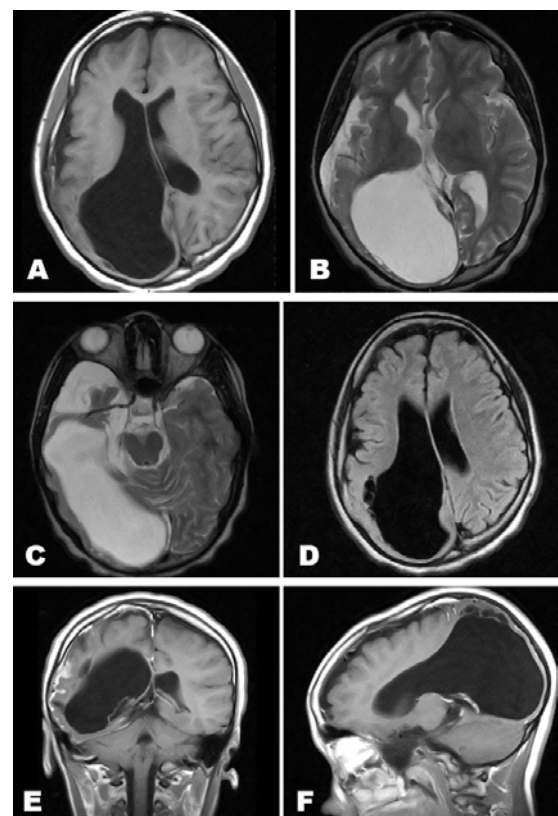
Brain MRI showing a large parenchymal cavity, meaning localized destruction of the cerebral parenchyma, in the right parieto-occipital area. Around it there are microcavities inside the parenchyma, with a bit of localized cortical atrophy, and also an arachnoid cyst situated in the anterior part of the right temporal lobe (Sylvian fissure). Altogether this setup constitutes irritative brain spines (A–D).
